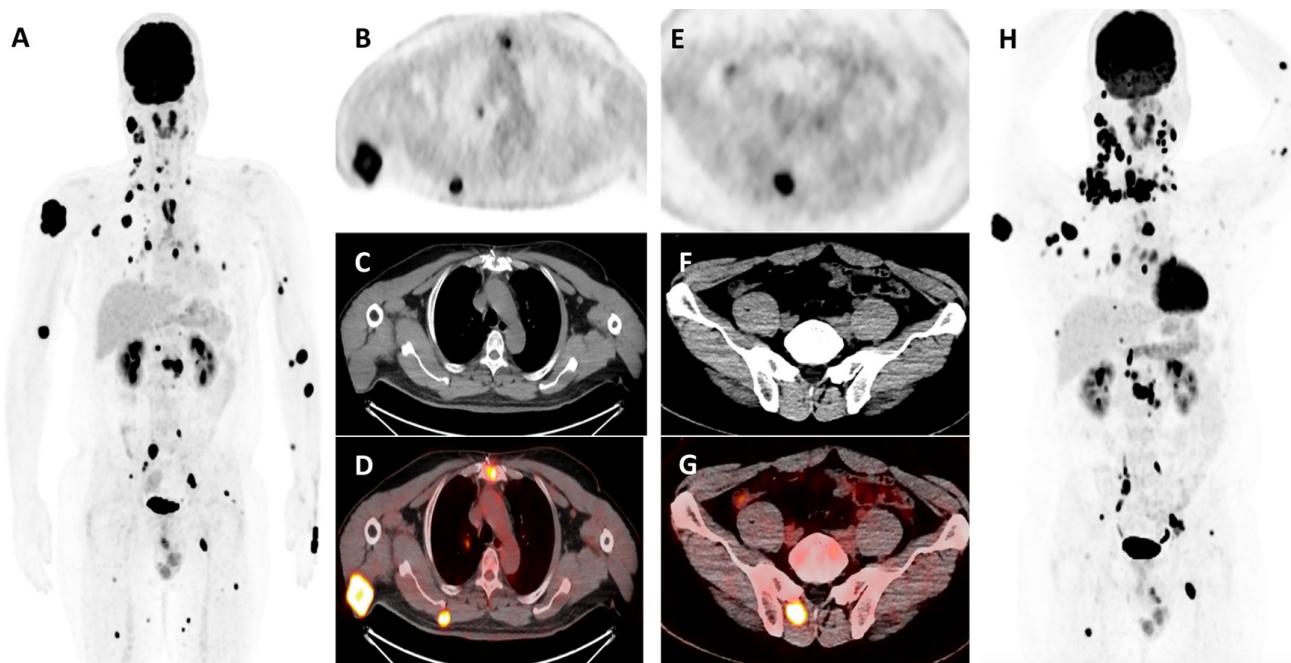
Subsequent ^{18}F -fluorodeoxyglucose positron emission tomography/computed tomography (^{18}F -FDG PET/CT) (A) revealed ^{18}F -FDG-avid malignancy in the thyroid bed with extensive nodal metastases in the neck, chest, and abdomen. Additionally, metastases were identified in the lungs, bones, and soft tissues of the bilateral upper limbs, prominently in the right posterior shoulder (B, C, and D axial view). There was also involvement in muscles, including the right trapezius, right intercostal, bilateral paraspinal, bilateral thigh, and left gluteus, with prominent involvement in the right paraspinal muscle (E, F, and G axial view). Following these findings, radioiodine therapy was discontinued, and the patient began treatment with the tyrosine kinase inhibitor (TKI) lenvatinib. After eight months on lenvatinib, a follow-up ^{18}F -FDG PET/CT demonstrated disease progression, with multiple new ^{18}F -FDG-avid lesions despite some regression in previously noted sites. The initial suppressed serum thyroglobulin (Tg) level was 34.8 ng/mL (thyroid stimulating hormone of 0.19 mIU/L), increasing to 96.8 ng/mL, before TKI initiation, indicating disease progression. Following TKI therapy, suppressed Tg levels decreased to 0.36 ng/mL on later follow-up before rising again to 268.0 ng/mL, suggesting ongoing disease activity. Distant metastases in differentiated thyroid carcinoma occur in approximately 5% to 10% of cases, typically affecting the lungs and bones (1). Less common sites of dissemination, such as the liver, brain, soft tissue, and muscle, often indicate dedifferentiation of the disease and may arise years after the initial diagnosis (2,3). Soft tissue and muscle metastases from papillary thyroid carcinoma are rare and frequently identified incidentally on imaging due to the asymptomatic nature of most cases (2,4). These metastases generally signify advanced and widely disseminated disease, as in this case (2,4). However, there are reports of solitary soft tissue and muscle metastases in some patients (3,5,6). Soft tissue and skeletal muscle are considered unfavorable environments for tumor proliferation due to factors such as anti-tumor cytokines (e.g., interleukin adenosine and leukemia inhibitory factor); the removal of lactic acid; mechanical disruption of tumor cells; inappropriate pH levels; variable blood flow; and continuous muscle motion (1,2,4,7,8). Nevertheless, soft tissue and muscle metastasis can occur via multiple mechanisms, including intramuscular lymphatic spread, hematogenous dissemination, and perineural transmission (7). In this context, ^{18}F -FDG PET/CT is crucial when serum Tg levels are disproportionately high and do not correlate with Iodine-131 (^{131}I) whole-body scan findings (9). It helps identify iodine-refractory or dedifferentiated lesions, revealing occult metastases not seen on ^{131}I imaging (9,10). In this case, the detection of soft tissue metastasis on ^{131}I whole-body scintigraphy, along with extensive hypermetabolic ^{18}F -FDG-avid lesions in unexpected sites, indicated a poor prognosis and shorter survival (1,2,8,9,10), necessitating a change in treatment strategy.
